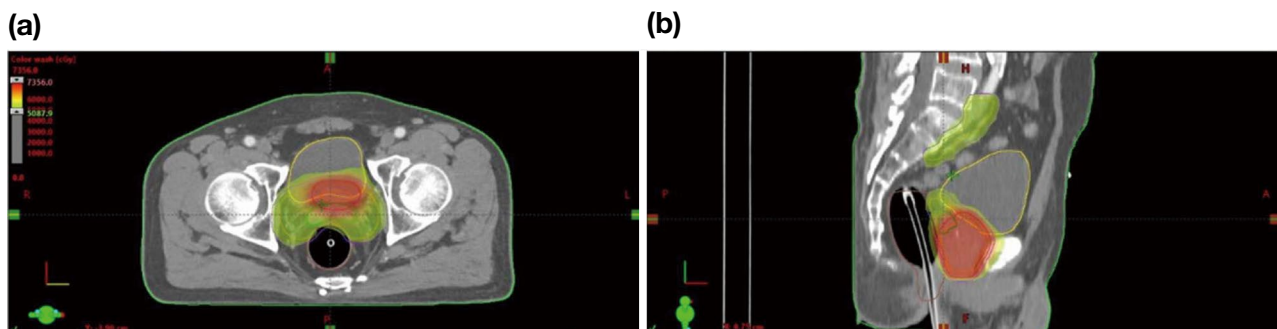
Axial (a) and sagittal (b) treatment planning CT images of a patient with an inserted endorectal balloon (ERB) during prostate radiotherapy. The inflated ERB is visible within the rectum, stabilizing the prostate position and reducing high-dose exposure to the rectum.
